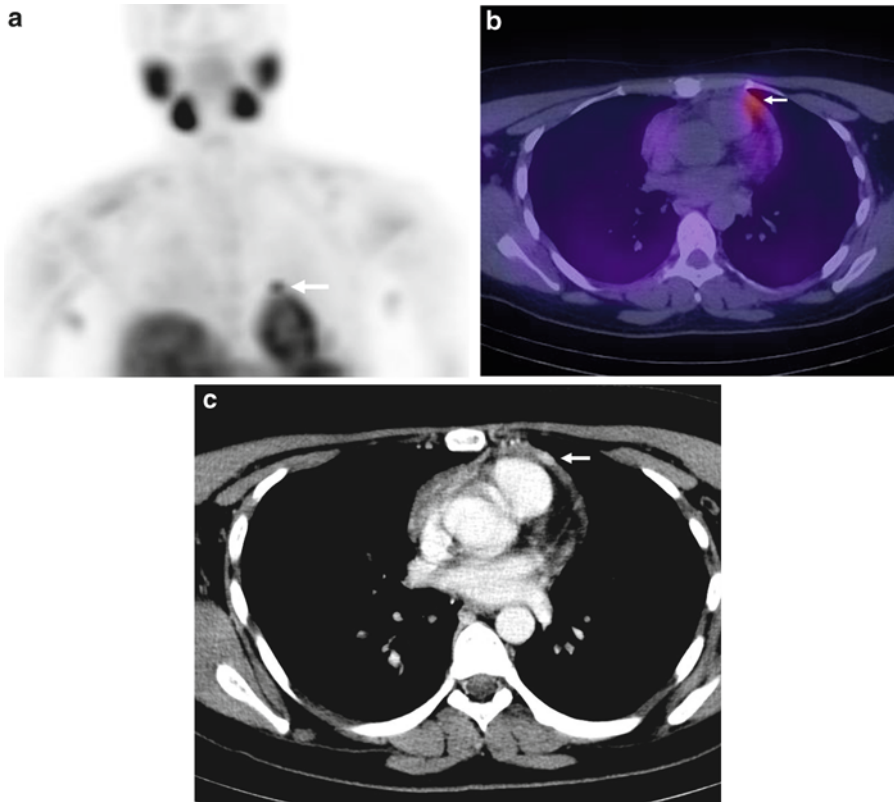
Ectopic pericardial parathyroid adenoma. (a) Planar sestamibi scan shows a small focal site of radiotracer activity (*arrow*) just superior to the myocardium (b). Transverse sestamibi SPECT/CT shows focal sestamibi activity (*arrow*) associated with the pericardium
